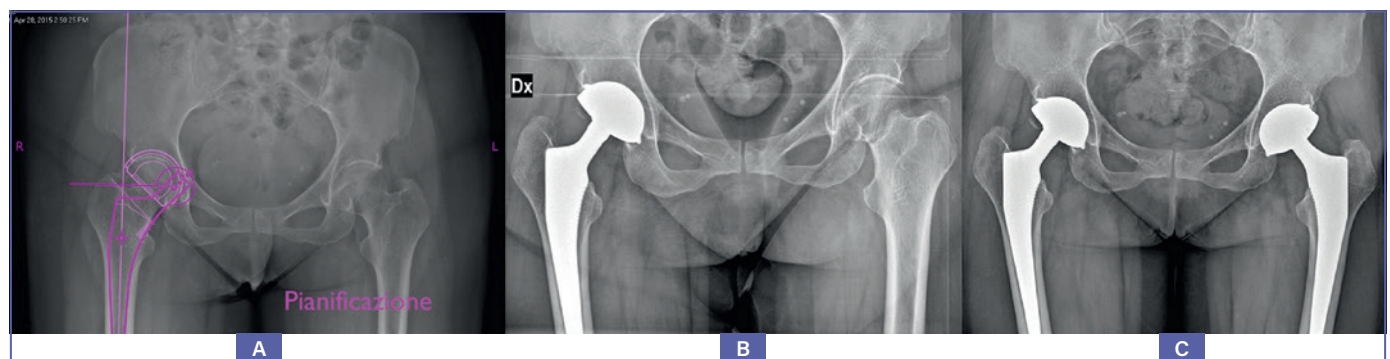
AP view pelvic X-rays. A) Right femoral neck fracture. Pre-operative planning; B) 1-year after DM implant on the right side + left femoral neck fracture; C) 2-years after DM implant on the right side + 1-year after DM implant on the left side.
